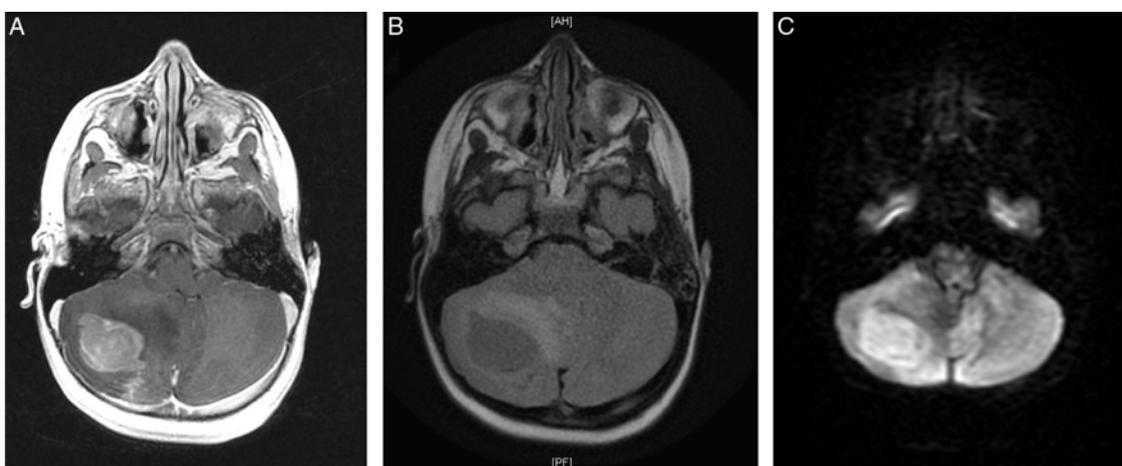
MRI confirmed a lesion in the right cerebellar hemisphere, with prominent contrast enhancement, with a linear focus of enhancement at the margin (A). FLAIR sequences showed moderate surrounding edema, crowding of the basal cisterns, and mass effect on the fourth ventricle (B). Axial multiplanar gradient echo sequences showed few punctate foci of susceptibility within the lesion in keeping with calcification or blood product (not shown) and DWI (C) and ADC images showed diffusion restriction, indicating hypercellularity (not shown).
